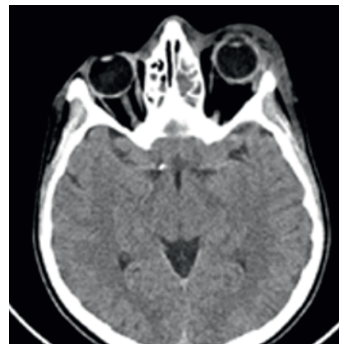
CT: Extensive eyelid edema on the left, with involvement of the orbit, at the level of the upper quadrants, in pre- and post-septal extra-conical topography. Extensive edema of the soft tissues of the nasal and anterior frontal region, with small gas foci.
